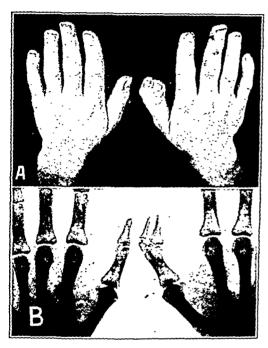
(case 3).—A, photograph of both hands, showing the bifid right thumb. Note also the radial deviation of the nail phalanges of both fifth fingers (clinodactylism). B, roentgenogram of the thumbs. Note the bifid right thumb; the radial member is definitely triphalangeal, while the ulnar member has a small third phalanx interposed between the nail and the proximal phalanx only on the radial side.
